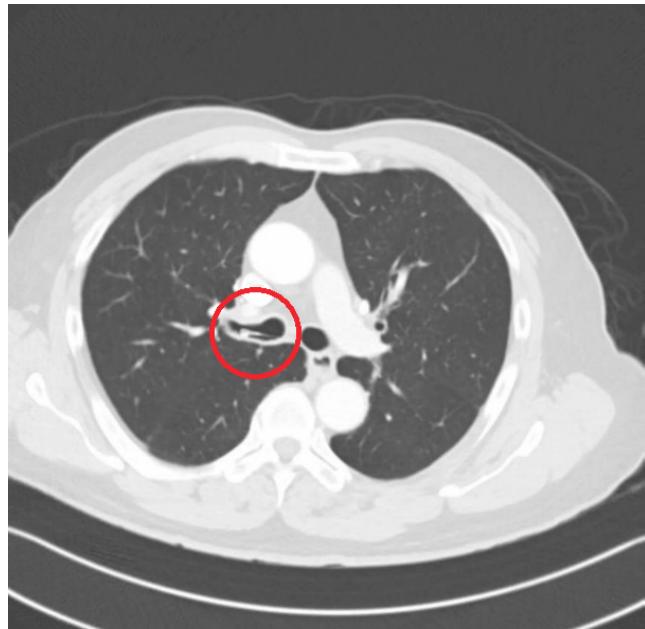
CT Thorax showing the V-shaped foreign body in the right main bronchus
